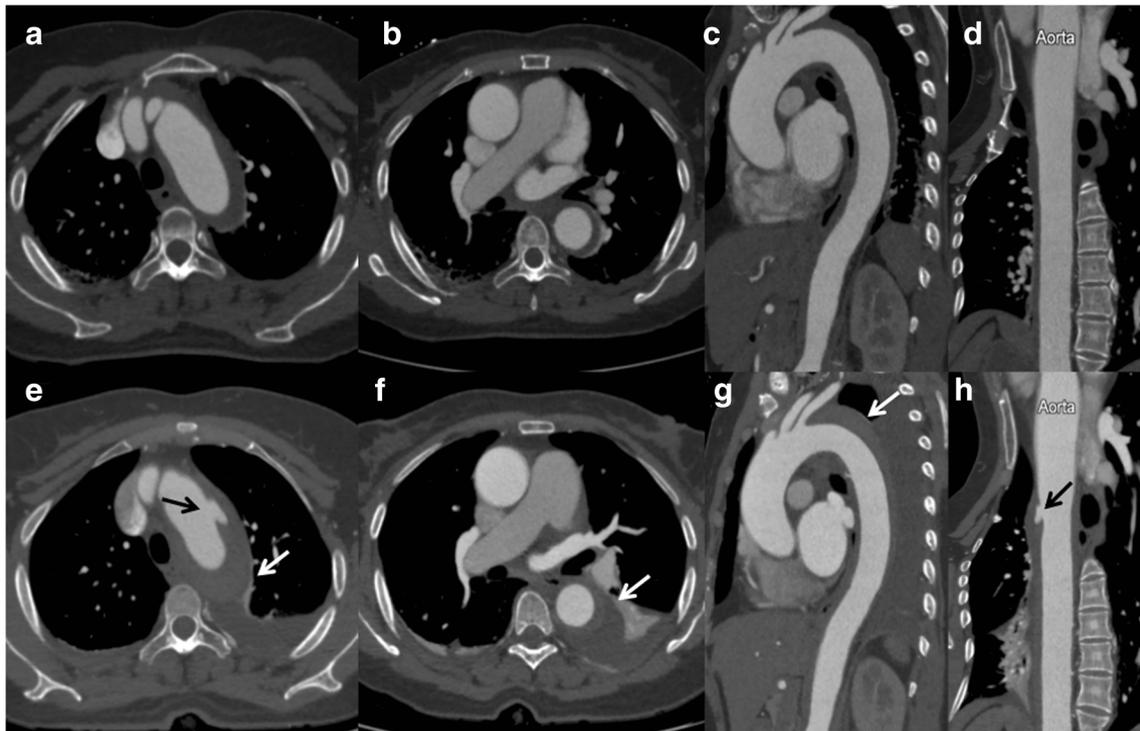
Progression of a representative case of type B IMH detected by serial CT. A 56-year-old woman with type B IMH underwent serial CT scans. Intramural hematoma at baseline was identified on the cross-sectional (a, b), multiplanar reformation (c), and curved planar reformation (d) images; initial medical therapy under careful surveillance was given. One week later, the follow-up CT images (e–h) showed significant
